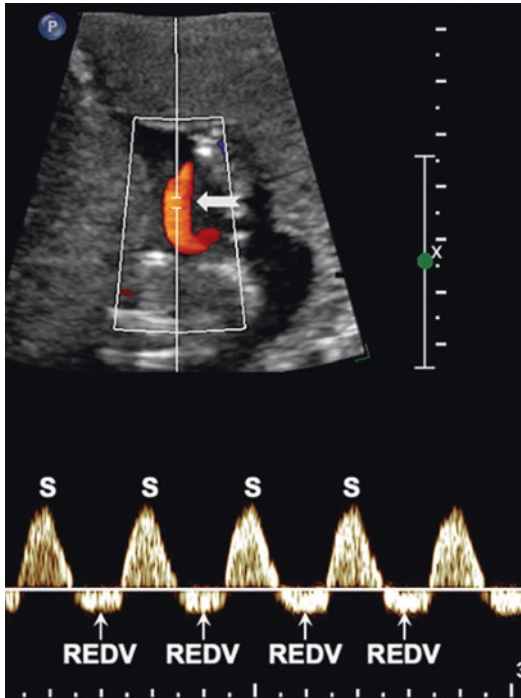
An example of reverse end-diastolic velocity in the umbilical artery. Top: Color Doppler-directed pulsed Doppler interrogation of the umbilical vessels. The white arrow points at the Doppler sampling location. Bottom: umbilical arterial Doppler waveforms. *S* peak systolic velocity, *REDV* reverse end-diastolic velocity
